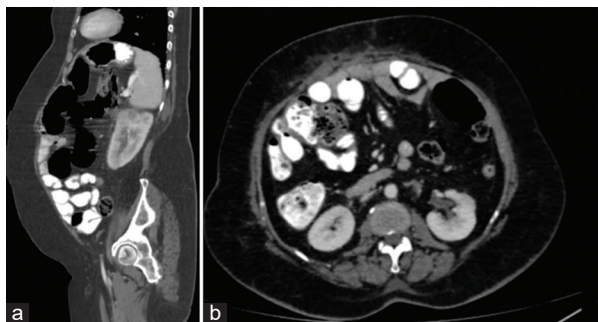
(a) Contrast enhanced CT showing normal enhancement of right kidney with interval resolution of right peri-nephric abscess. Interval appearance of ill-defined hypo-enhancing areas at the upper pole of left kidney with peri-nephric fat stranding. Proximal tip of DJ stent seen within left renal pelvis; (b) Axial contrast CT showing normal enhancement of left kidney with interval resolution of perinephric fat stranding and thickening of left pararenal fascia. Interval reduction in dilatation of left renal pelvis is seen when compared to previous CT. Previously seen left DJ stent has been removed.
